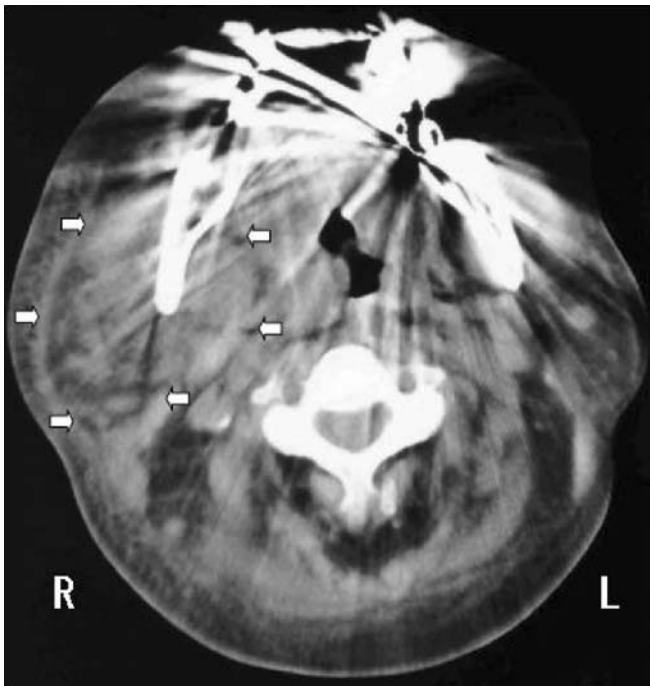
Cranial computed tomography. Abscess formation is visible subcutaneously in the right mandibular region over the parapharyngeal crevice (the arrows show abscess)
